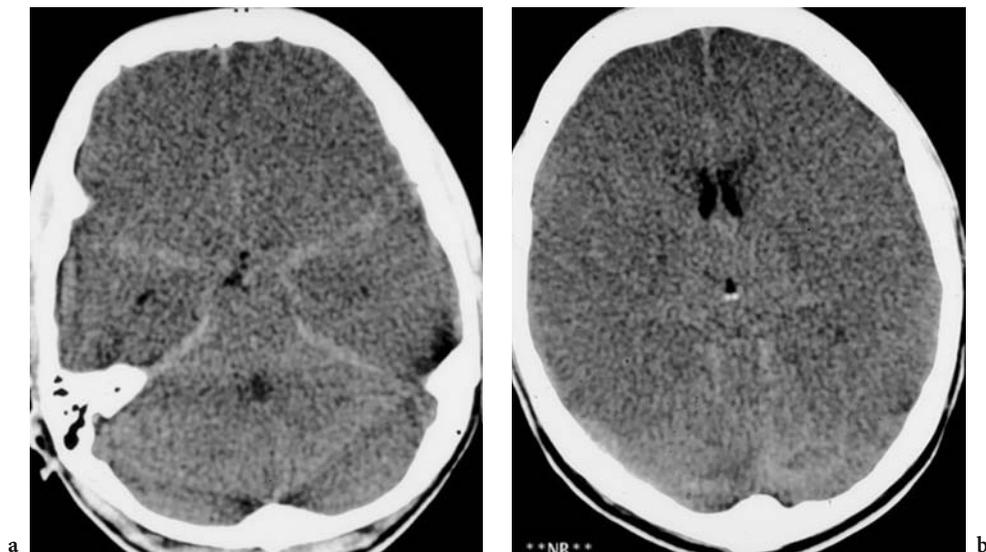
Severe hypoxia and brain edema mimicking basal SAH on CT
